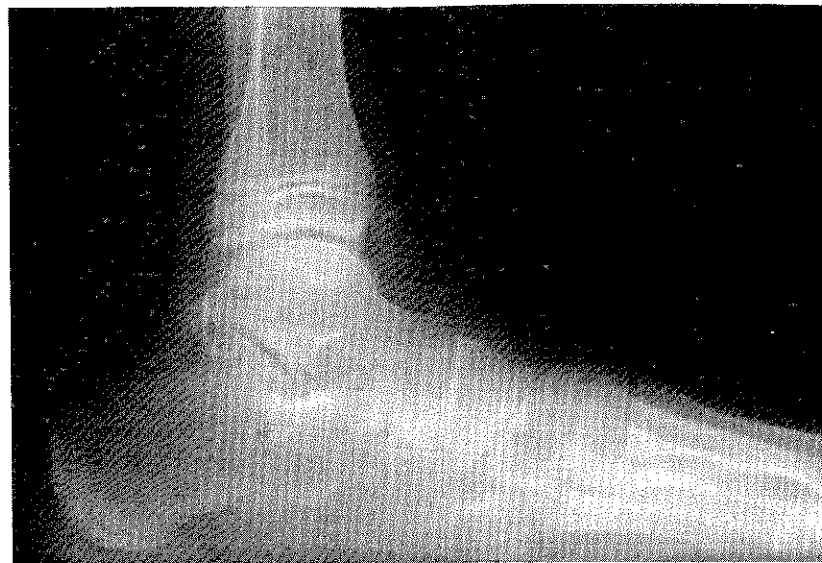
Postoperative radiograph showing improved talar declination angle, increased calcaneal inclination, and decreased talonavicular fault. The position of the STA-peg is also visible.
